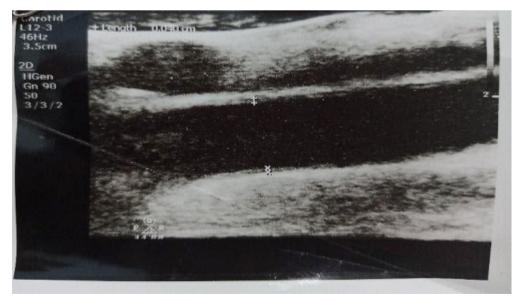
Doppler ultrasound of carotid artery
